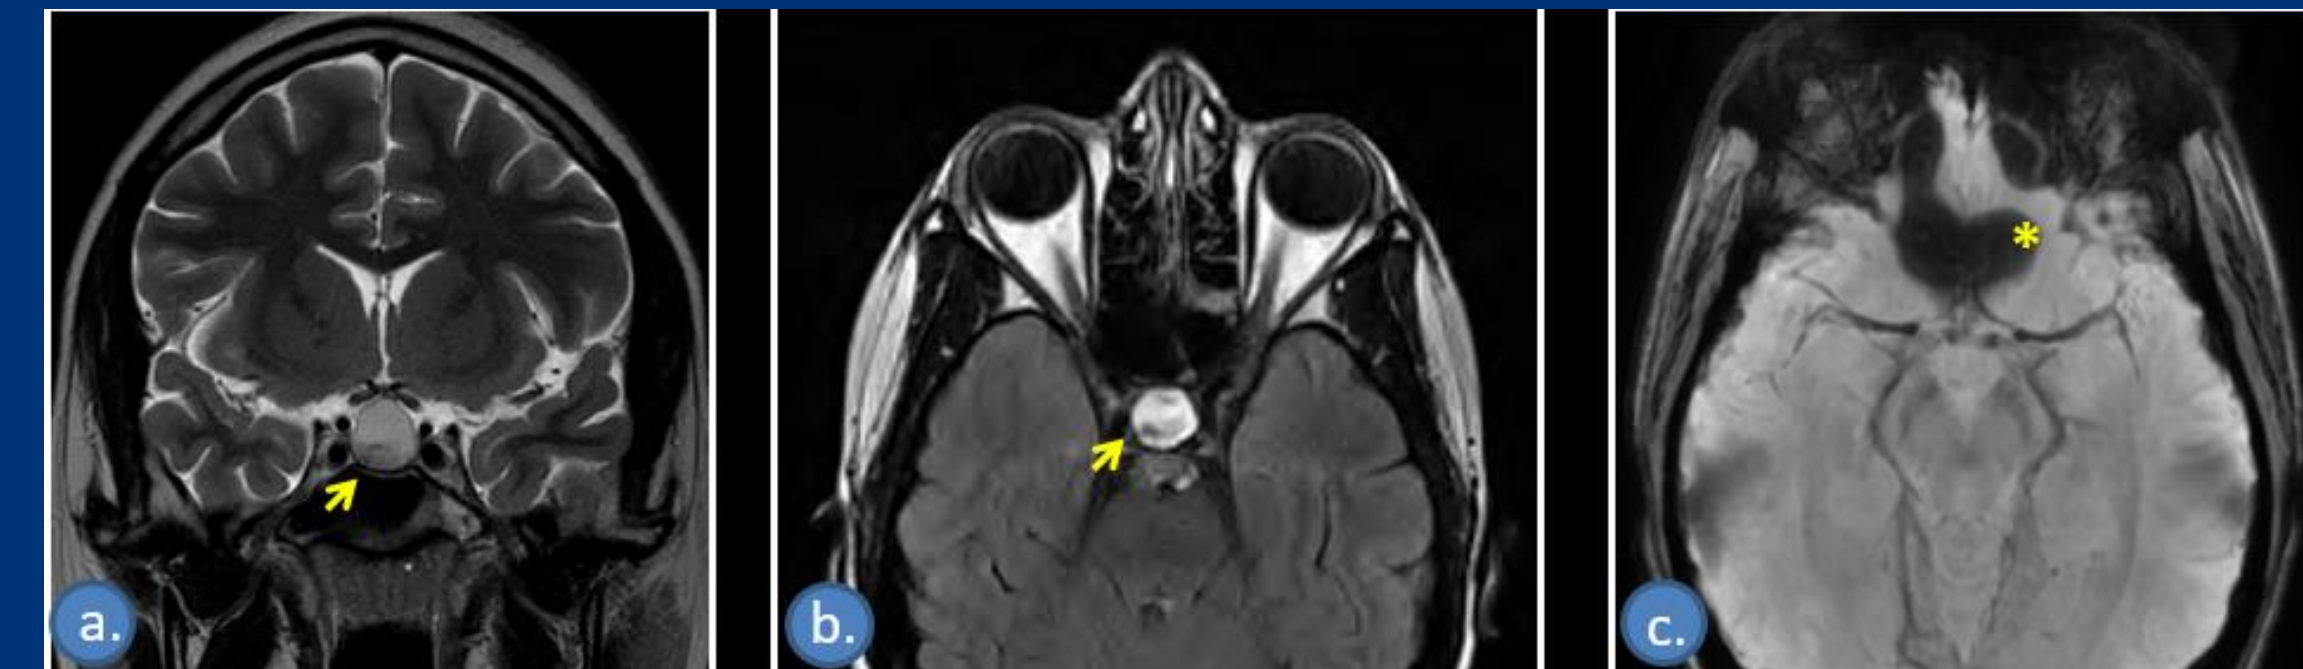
MRI Brain without and with IV contrast. There is a cystic intrasellar or suprasellar mass (arrow). a and b. The mass shows a grossly stable post surgical appearance, being intermediately signal on T2-weighted and hyperintense on FLAIR. c. Axial GRE* shows diffuse susceptibility artifact, suggestive of blood products (*)
